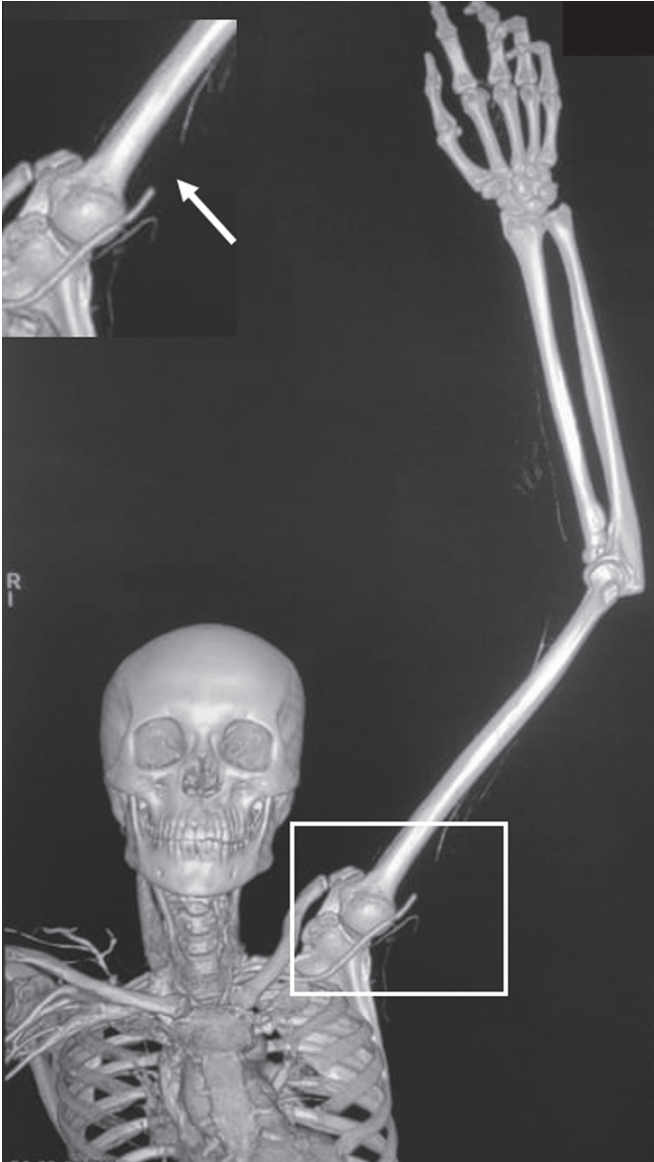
Spiral computed tomography angiography (coronal section) showing normal opacification of the left subclavian artery and the axillary artery and non-opacification of the left brachial artery (arrow)
